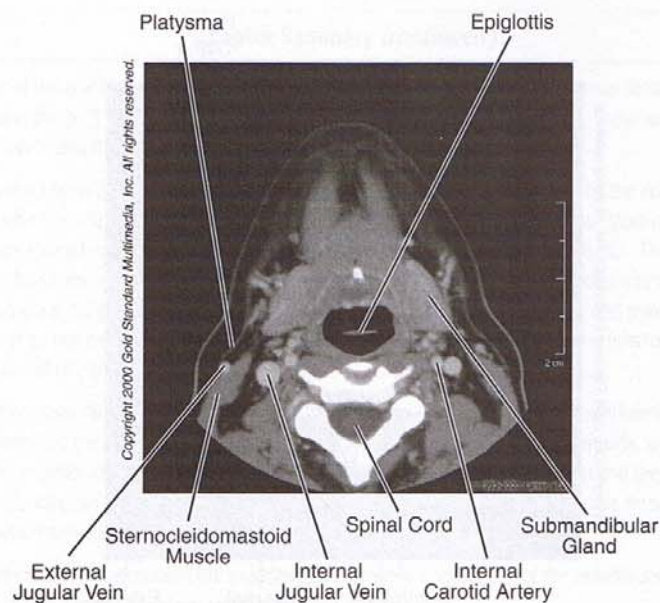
Head and Neck: CT, Neck at C₂ Vertebra
